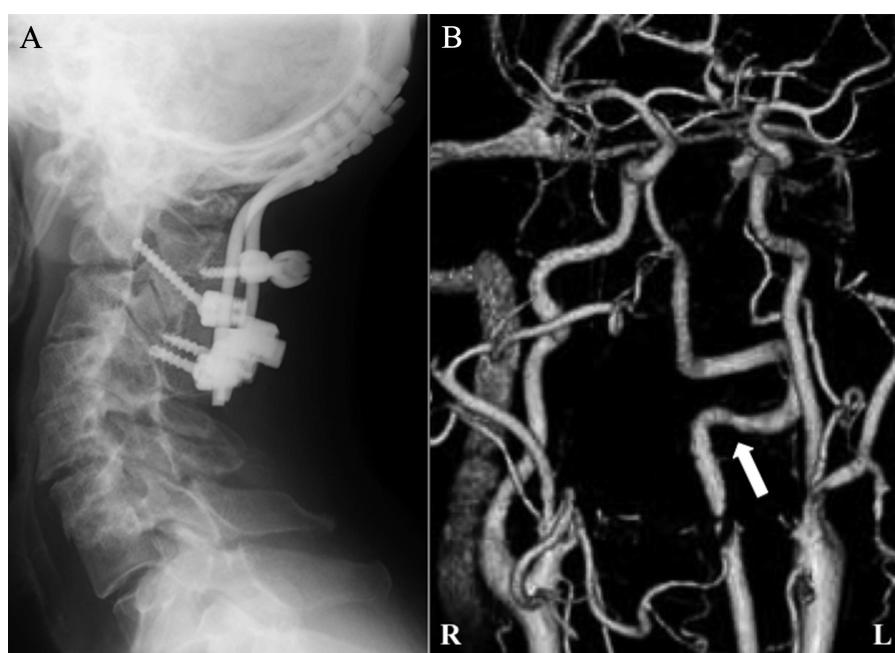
Postoperative lateral radiograph of the cervical spine (A) and an oblique view of 3-dimensional computed tomography angiography (B). Computed tomography angiography reveals complete disappearance of the stenosis of the left V3 portion (arrow) compared with preoperative left vertebroarteriography (Figure 2C).
